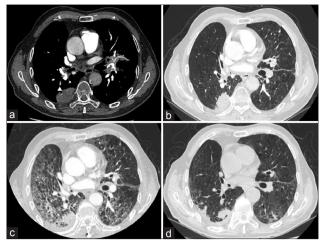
Chest computed tomography. (a and b) Pulmonary embolism (arrow) and metastasis (triangle) on the day of admission. (c) New bilateral infiltration and ground-glass attenuations on day 8 after admission. (d) The infiltration resolved 2 weeks after methylprednisolone treatment.
